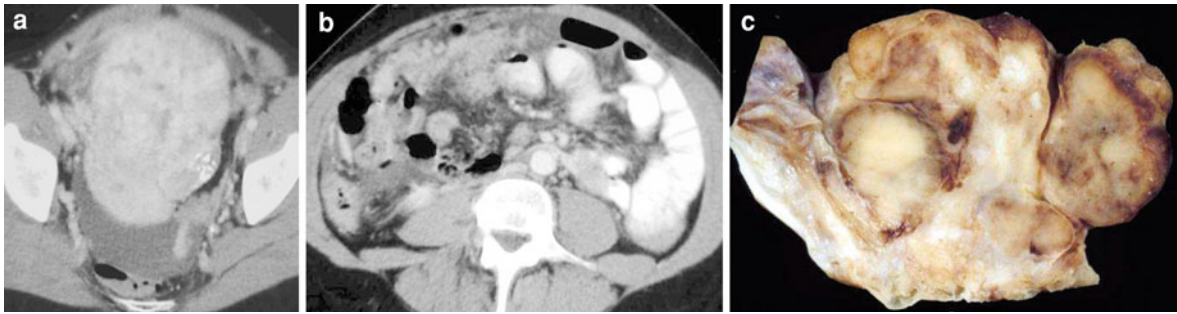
Metastatic goblet cell carcinoid tumor of the appendix. Contrast-enhanced CT image shows (a) a large, heterogeneously enhancing pelvic mass that encases the ovaries, making determination of appendiceal origin difficult. A more cephalad
